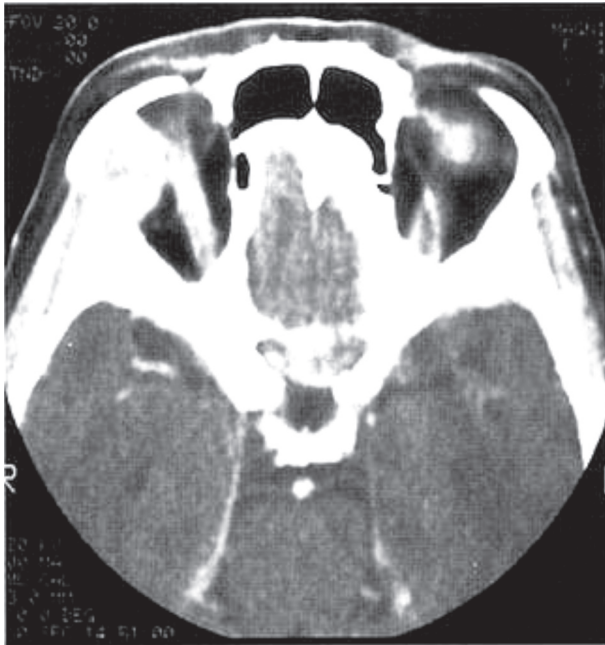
CT scan from 2002 y. of head and orbit shows right orbital tumor
